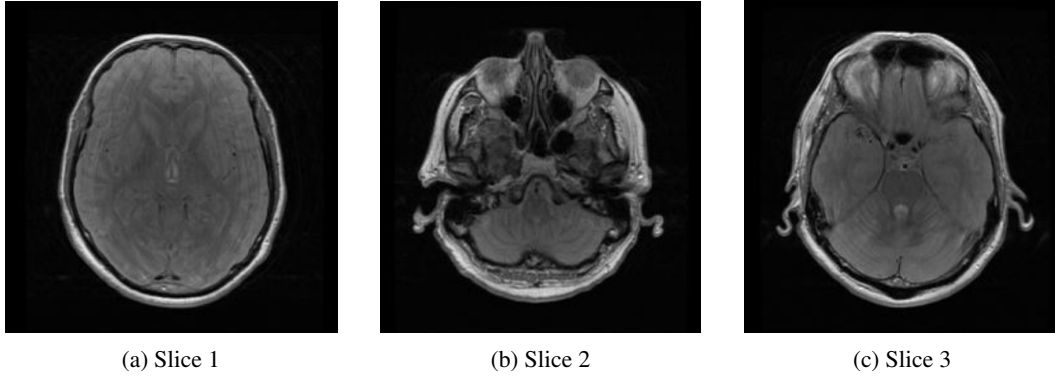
Example MRI Slices Without Segmentation
